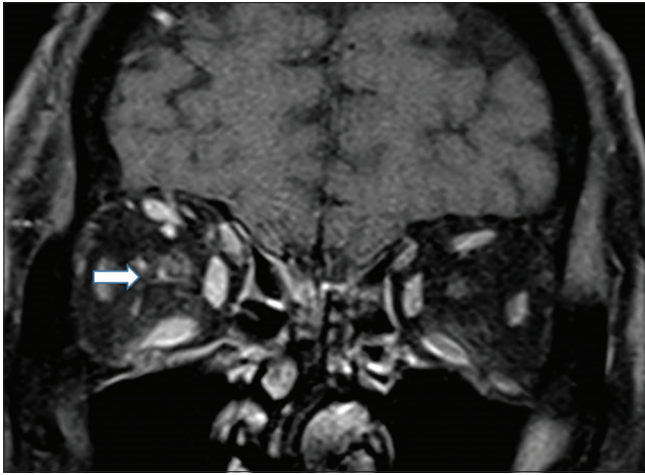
Fat-suppressed and contrast-enhanced magnetic resonance imaging showing right peri-optic nerve sheath enhancement
